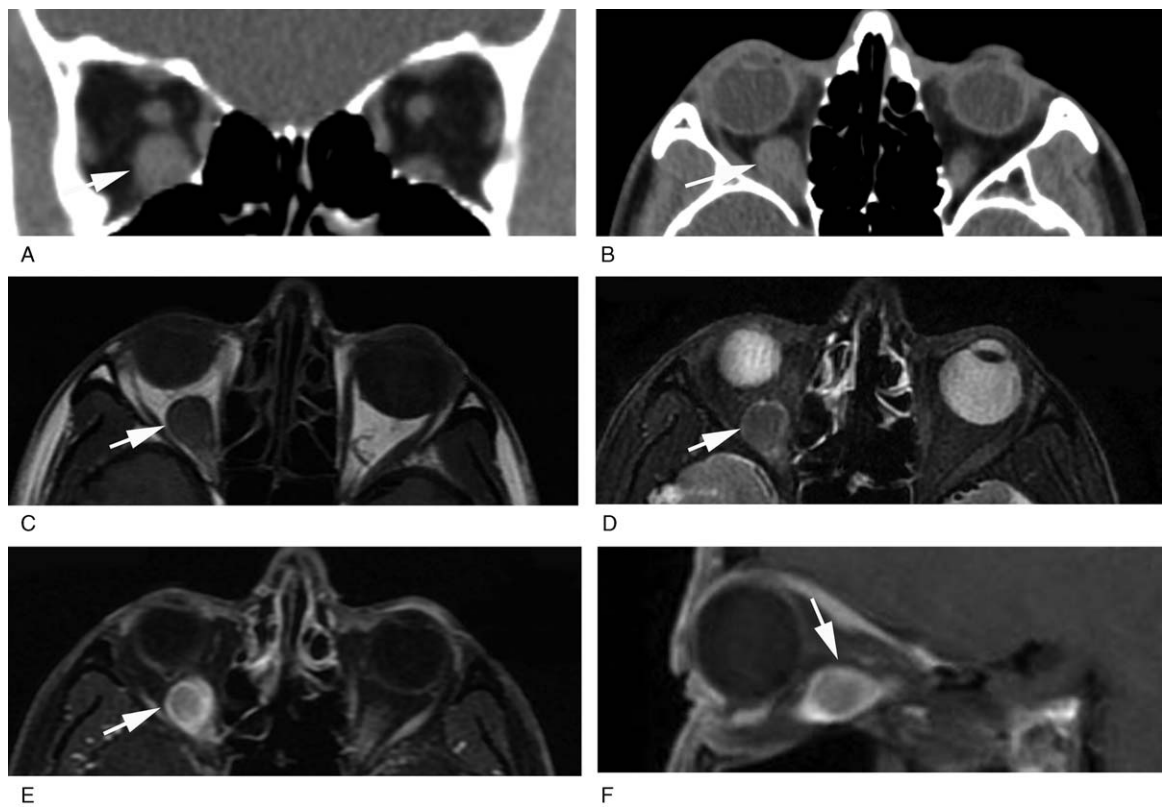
(A, B) Orbital computed tomography(CT) scanning showed enlargement of the right inferior rectus muscle infiltrated by a muscle-density tumor which was about $11 \times 17 \times 7$ mm³. (C, D) An axial magnetic resonance images (MRI) view of the orbit revealed a nodule-like tumor derived from the inferior rectus muscle, which was slightly hypo-intense to the extraocular muscles on T1W with a very low central intensity on T2W and a higher intensity along the periphery. (E, F) Enhanced MRI after intravenous contrast administration showed that the tumor was significantly enhanced in the periphery but only slight enhanced in the center. The tumor was very closed to the optic nerve (arrows) and extended into the orbital apex. The mass was with significantly enhanced peripherally and slightly enhanced in the center.
